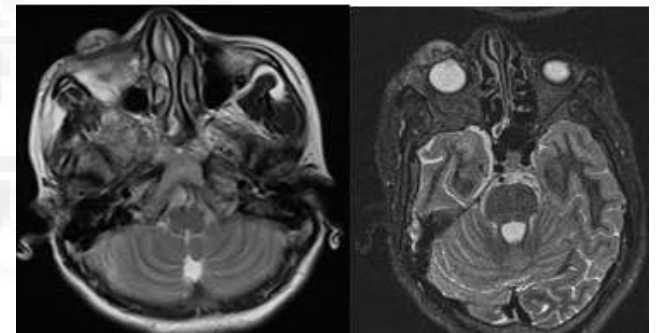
MRI Orbit shows T2 intermediate signal lesion noted in the anterior superior aspect of the right eye globe consistent with Capillary hemangioma.
